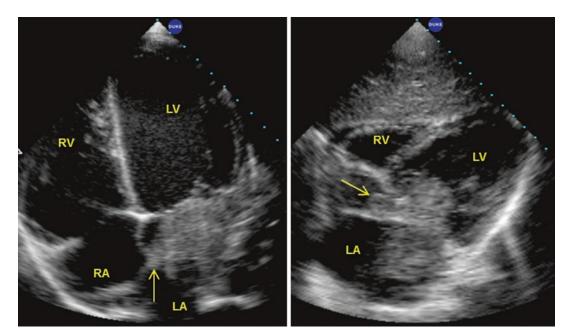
The left panel shows an apical four-chamber view of the anchor point of an atrial myxoma in the same patient as seen in Fig. 28.5 (arrow). Slight inferior angulation of the interrogating probe demonstrates a portion of the tumor protruding through the foramen ovale, thus revealing the fact that the tumor is actually biatrial. It is
